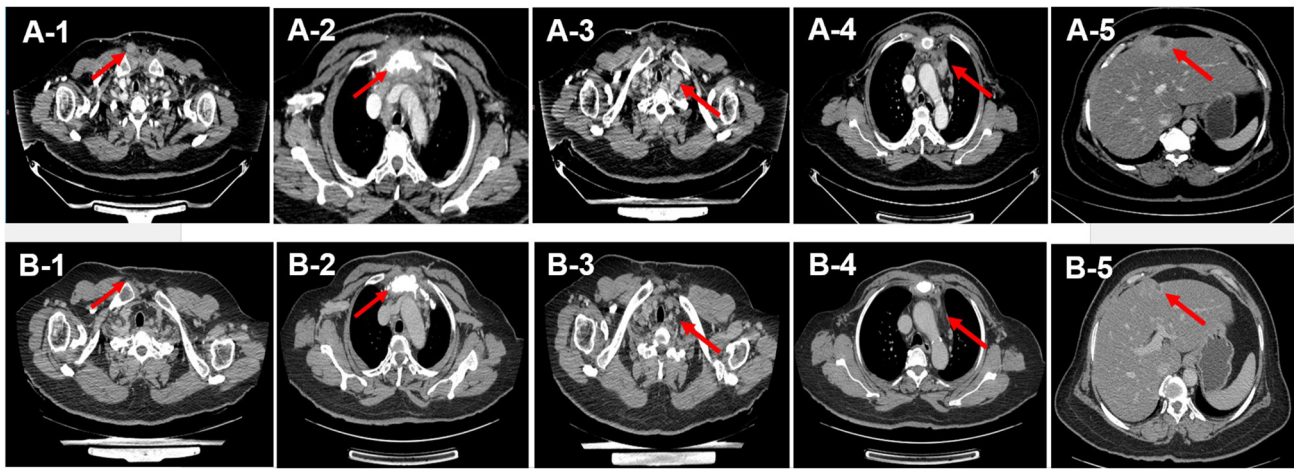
Chest and abdominal CT scans showing response to oral vinorelbine combined with apatinib: Baseline images and images after two cycles of treatment are shown. The efficacy was evaluated as partial response. (A-1, B-1) Chest wall metastasis, (A-2, B-2) Sternal bone destruction with soft tissue mass formation, (A-3, B-3) Left supraclavicular lymph node metastasis, (A-4, B-4) Mediastinal lymph node metastasis and (A-5, B-5) Liver metastasis. Metastatic lesion size reduction: (A-1) 1.8x1.4 cm to (B-1): 0 cm, (A-2) 4.2x3.5 cm to (B-2): 1x1 cm, (A-3) 2.0x2.5 cm to (B-3): 1.2x1.0 cm, (A-4) 2.2x1.5 cm to (B-4): 0.8x0.5 cm and (A-5) 3.0x3.0 cm to (B-5): 1.0x0.5 cm. Red arrows indicate metastases. CT, computed tomography.
